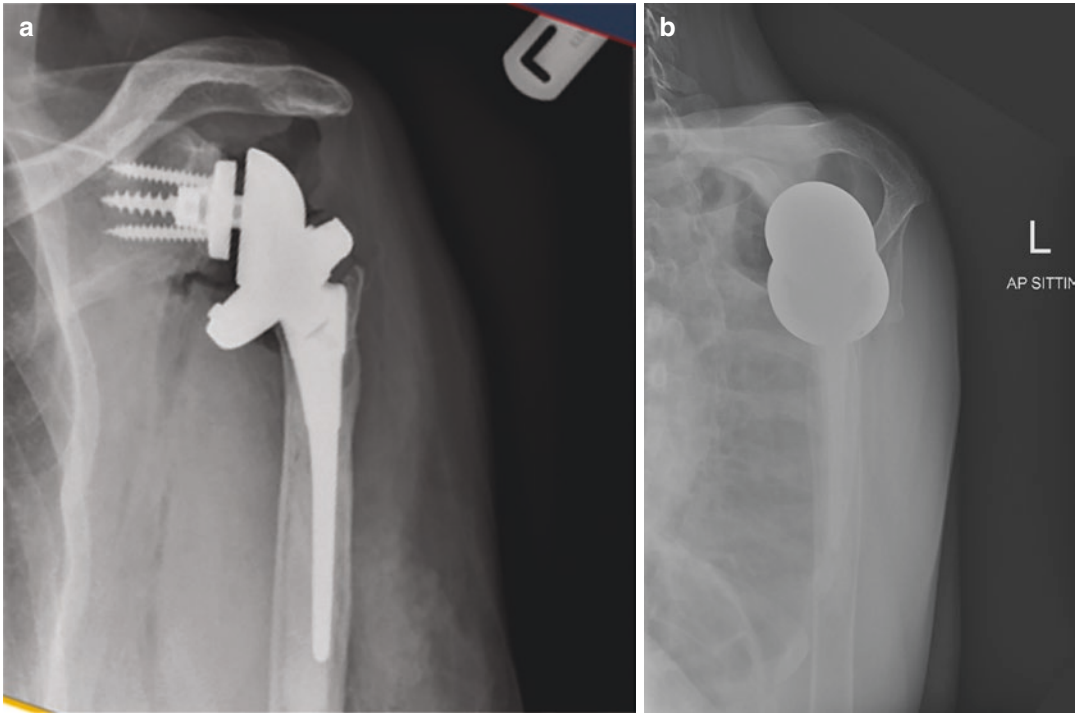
(a and b) Postoperative X-rays showing replacement of the necrotic humeral head with a total reverse shoulder arthroplasty
